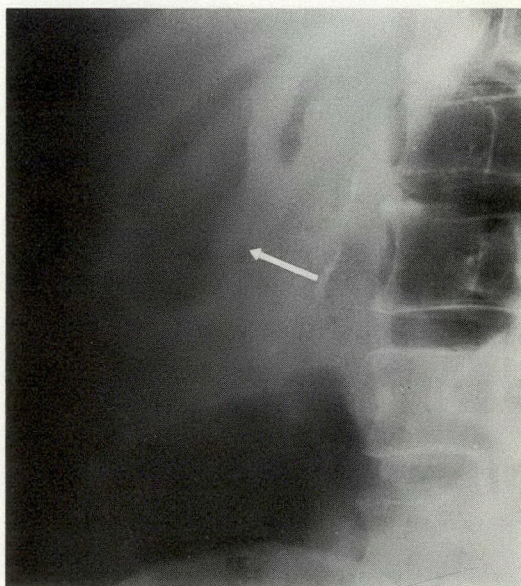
Cas no 2. Radiographie simple de l'abdomen, qui montre une vésicule biliaire pleine d'air (flèche).
